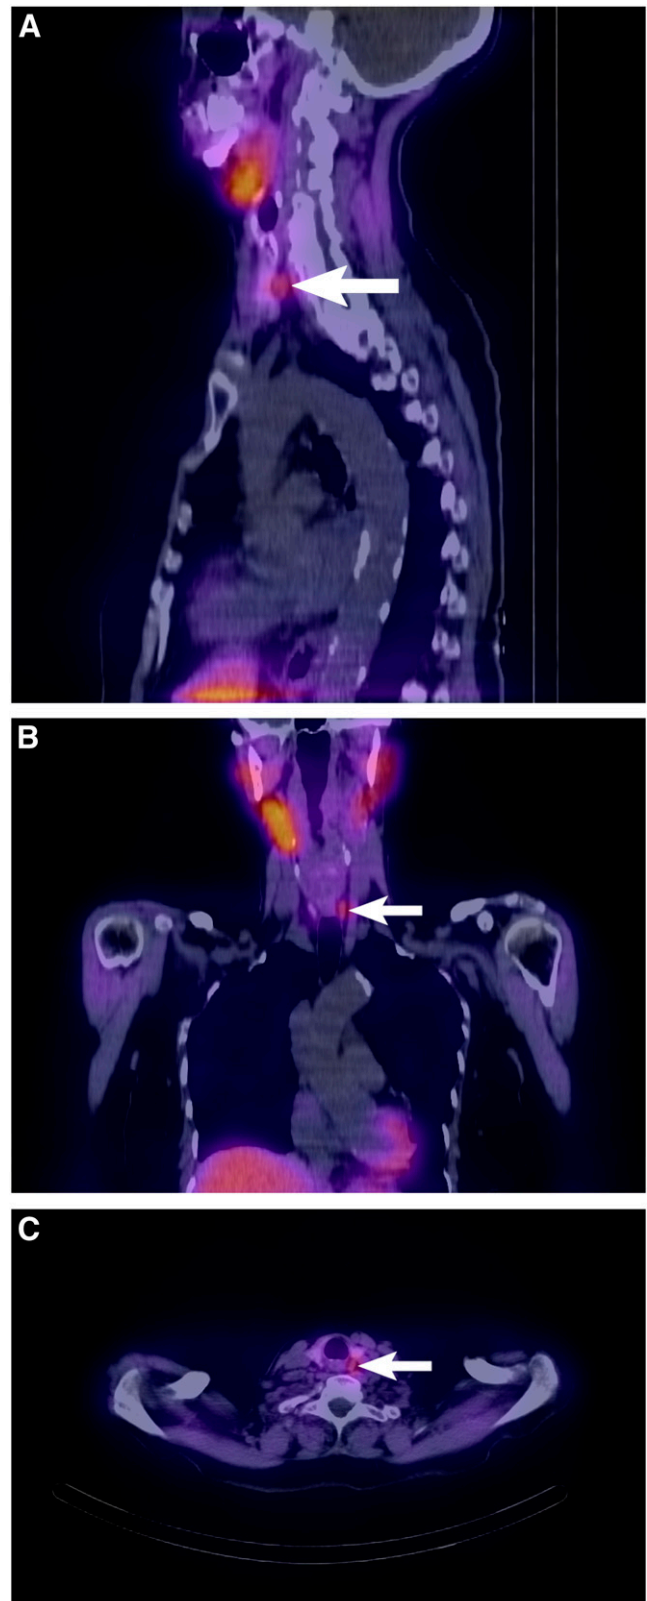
Scans performed on 71-y-old woman with primary hyperparathyroidism. Selected fused SPECT/CT sagittal (A), coronal (B), and transverse (C) tomograms demonstrate focus of residual activity associated with soft-tissue nodule (arrow) located posterior to right thyroid lobe. At surgery, residual activity was found to represent 400-mg parathyroid adenoma.
